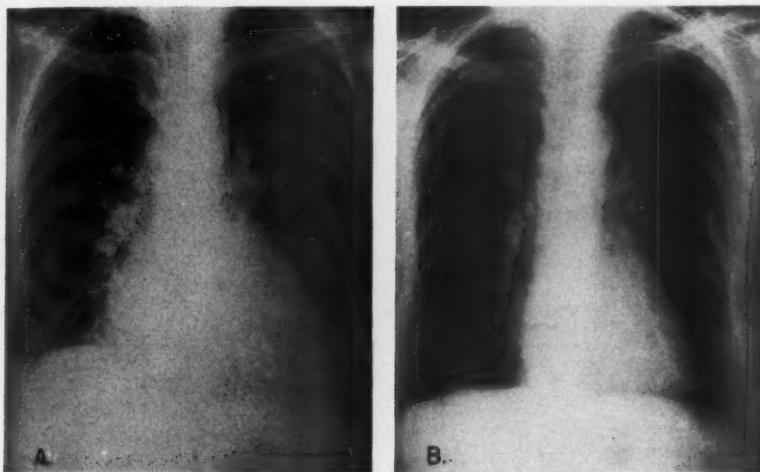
Case #1, M. B. (A). Preoperative roentgenogram of chest showing cardiac enlargement, pulmonary congestion and some fluid at the right base. (B). Postoperative roentgenogram of chest showing clearing of the signs of congestive failure.
